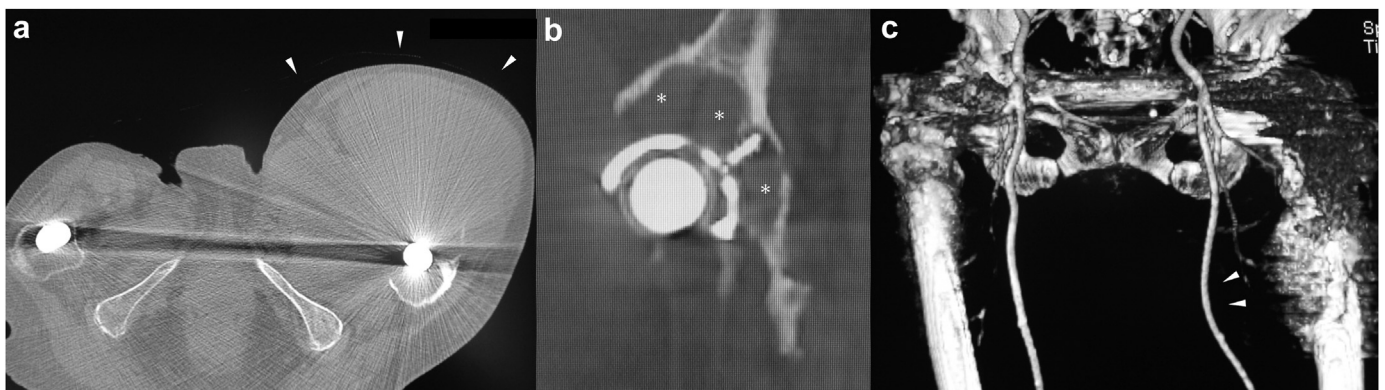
Preoperative CT.
